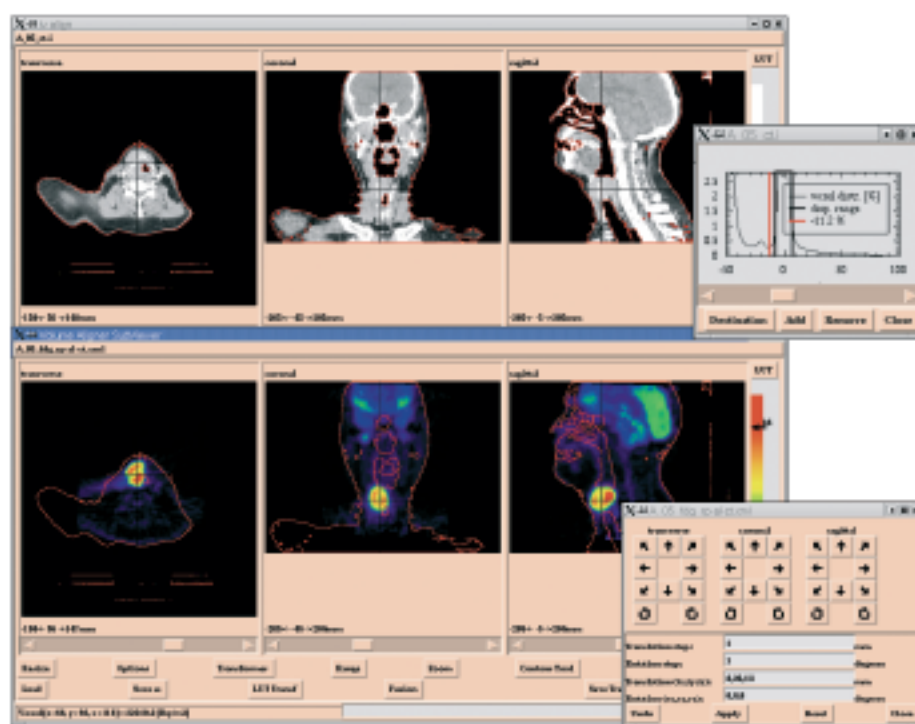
Screen dump of the coregistration window. In this example, automatic segmentation of the CT volume (upper three slices) was performed based on selection of a particular threshold (upper right window) and overlay on the PET volume (bottom three slices). Interactive translations and rotations (lower right window) allow visual matching between the two modalities.
